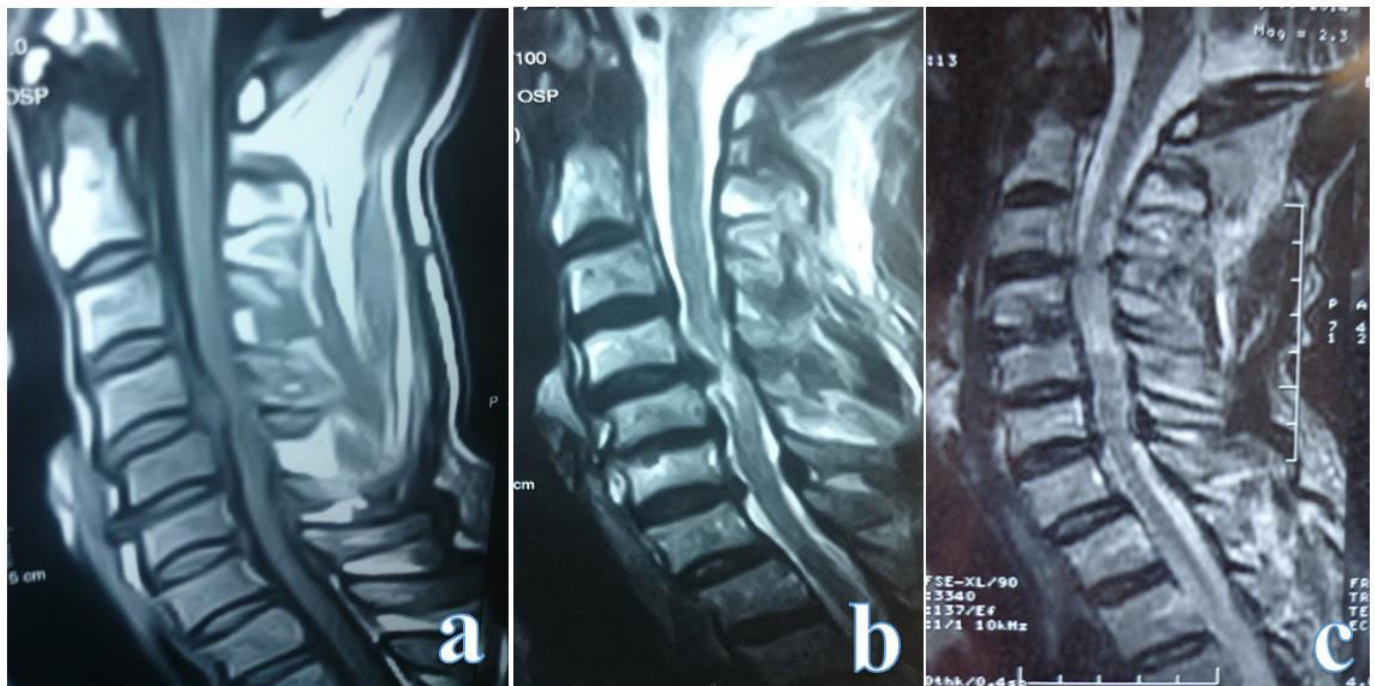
A & B Preoperative MRI cervical spine T1 and T2 sagittal WI reveals C4-5 central disc herniation obliterating anterior subarachnoid space and compromising ventral aspect of spinal cord kinking it with intramedullary hyperintense signal on T2WI impressive of compressive myelopathy. C Post ACDF surgery T2WI sagittal WI reveals almost spinal cord decompression with relative restoration of anterior subarachnoid space.
